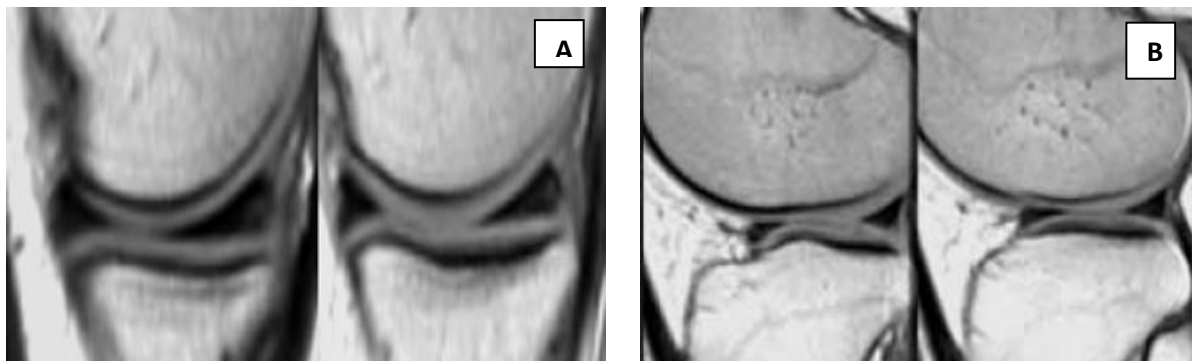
MRI Sagittal view of (A) Normal bow-tie appearance of medial meniscus (Posterior horn is larger than anterior horn). (B) Normal bow-tie appearance of lateral meniscus (both posterior and anterior horn are of same size)
